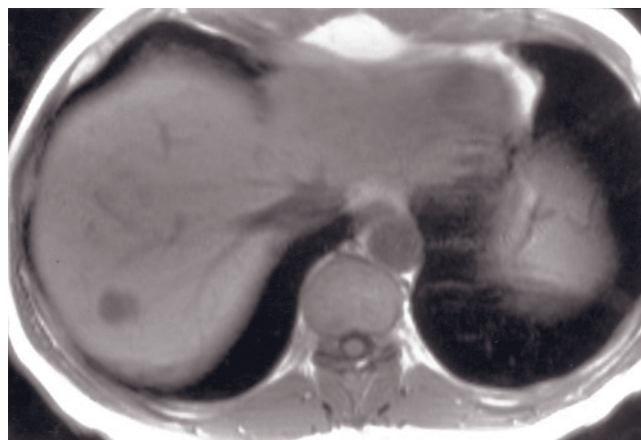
Medium-sized hemangioma, Type 2 enhancement. T2-weighted fat-suppressed ETSE (a), SGE (b), and immediate (c) and 5-min (d) postgadolinium SGE images demonstrate a well-defined, round lesion that is high signal on T2-weighted image (a) and moderately low signal on T1-weighted image (b) and enhances in a peripheral nodular fashion on early image (c) with complete filling of the entire lesion on the late image (d), consistent with hemangioma.
